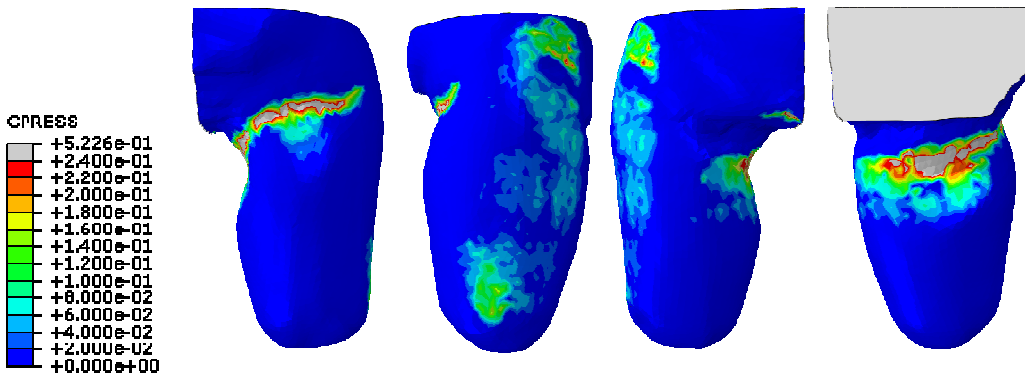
Pressure map after the loading phase using the residuum model reconstructed from MRI.
